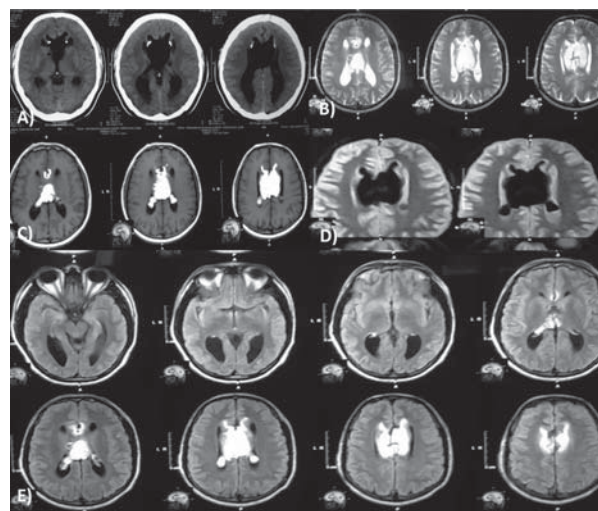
A) CT head axial showing hypodense lesion in pericallosal region with tiny calcifications, B) the same pericallosal lesion appearing hyperintense in T1WI image, C) hyperintense in T2WI image, D) hypointense in Fat suppression image and E) hyperintense FLAIR Image
